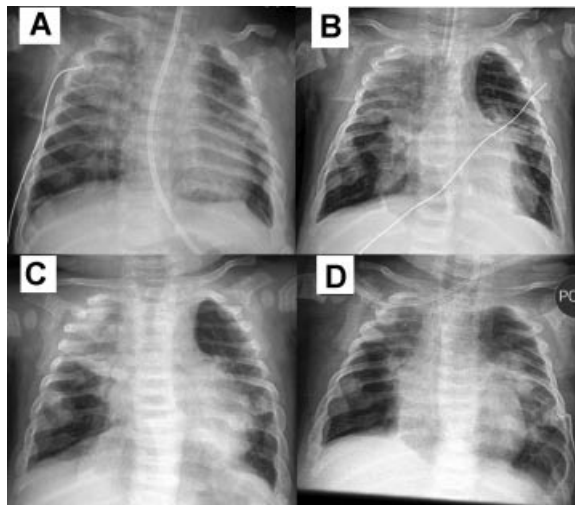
Chest radiographs demonstrating multiple rib fractures and diffuse areas of wandering atelectasis. These films were taken at 3 months (A), 6 months (B), and 7 months (C) of age. Aeration of the right upper and left lower lobes improved 48 hr after starting IPV therapy (D).
